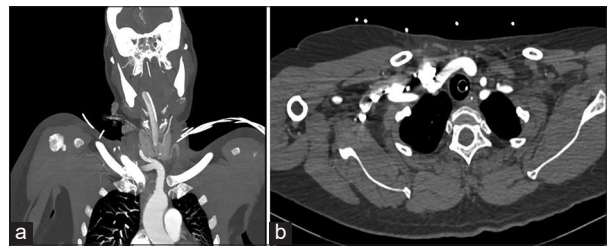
(a) Computed tomography (CT) angiogram showing coronal view of high-riding brachiocephalic artery; (b) CT angiogram showing axial view of high-riding brachiocephalic artery
